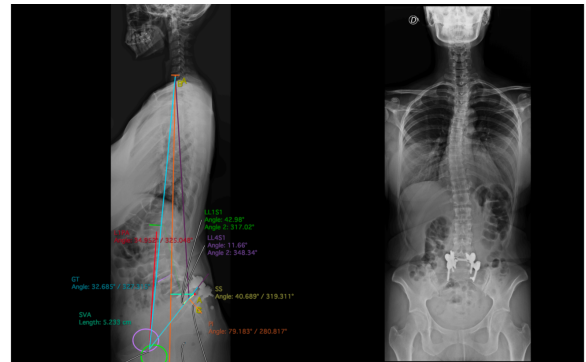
Preoperative panoramic X-ray indicating sagittal imbalance with severe hypolordosis with severe hypolordotic maldistribution, moderate pelvic retroversion and moderate positive malignment.
